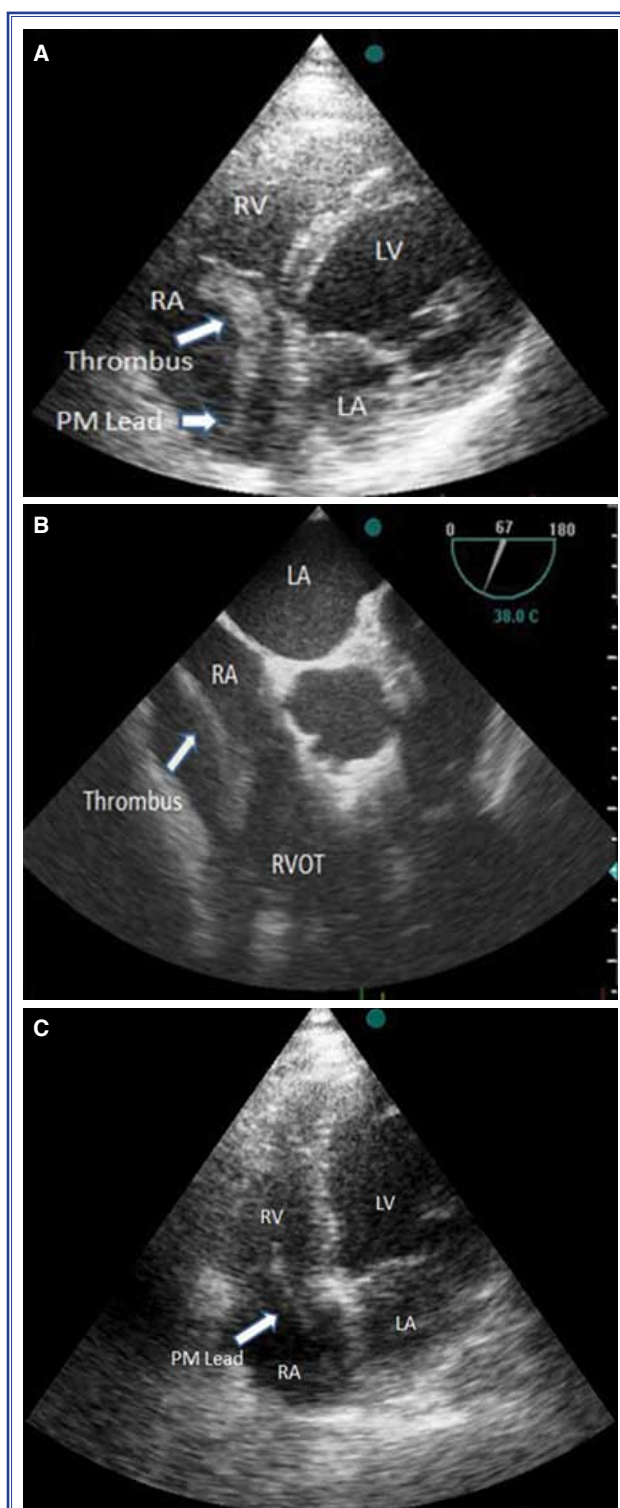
Transthoracic echocardiogram (TTE) showing (A) a large, mobile thrombotic mass in the right atrium (RA); (B) the RA attached to the PM lead and prolapsing into the RV outflow tract; (C) the thrombus has disappeared. Echocardiograms showing a PM lead in the RA and RV. LV: Left ventricle; LA: Left atrium; PM: Pacemaker; RV: Right ventricle; RA: Right atrium.
